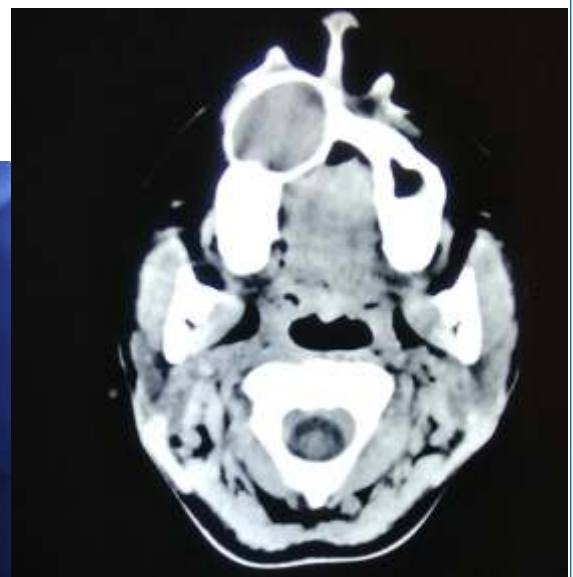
CT image showing Radicular Cyst
